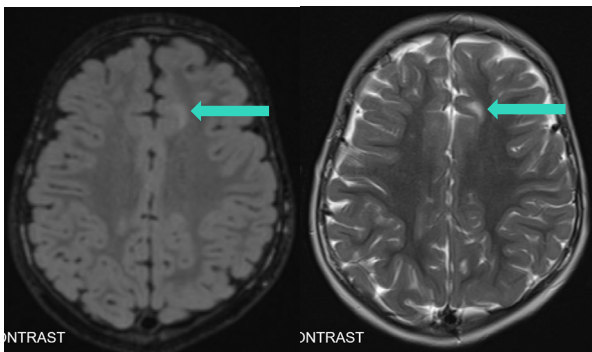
T2 (left) and FLAIR (right) MRI sequences demonstrate left focal cortical dysplasia.
